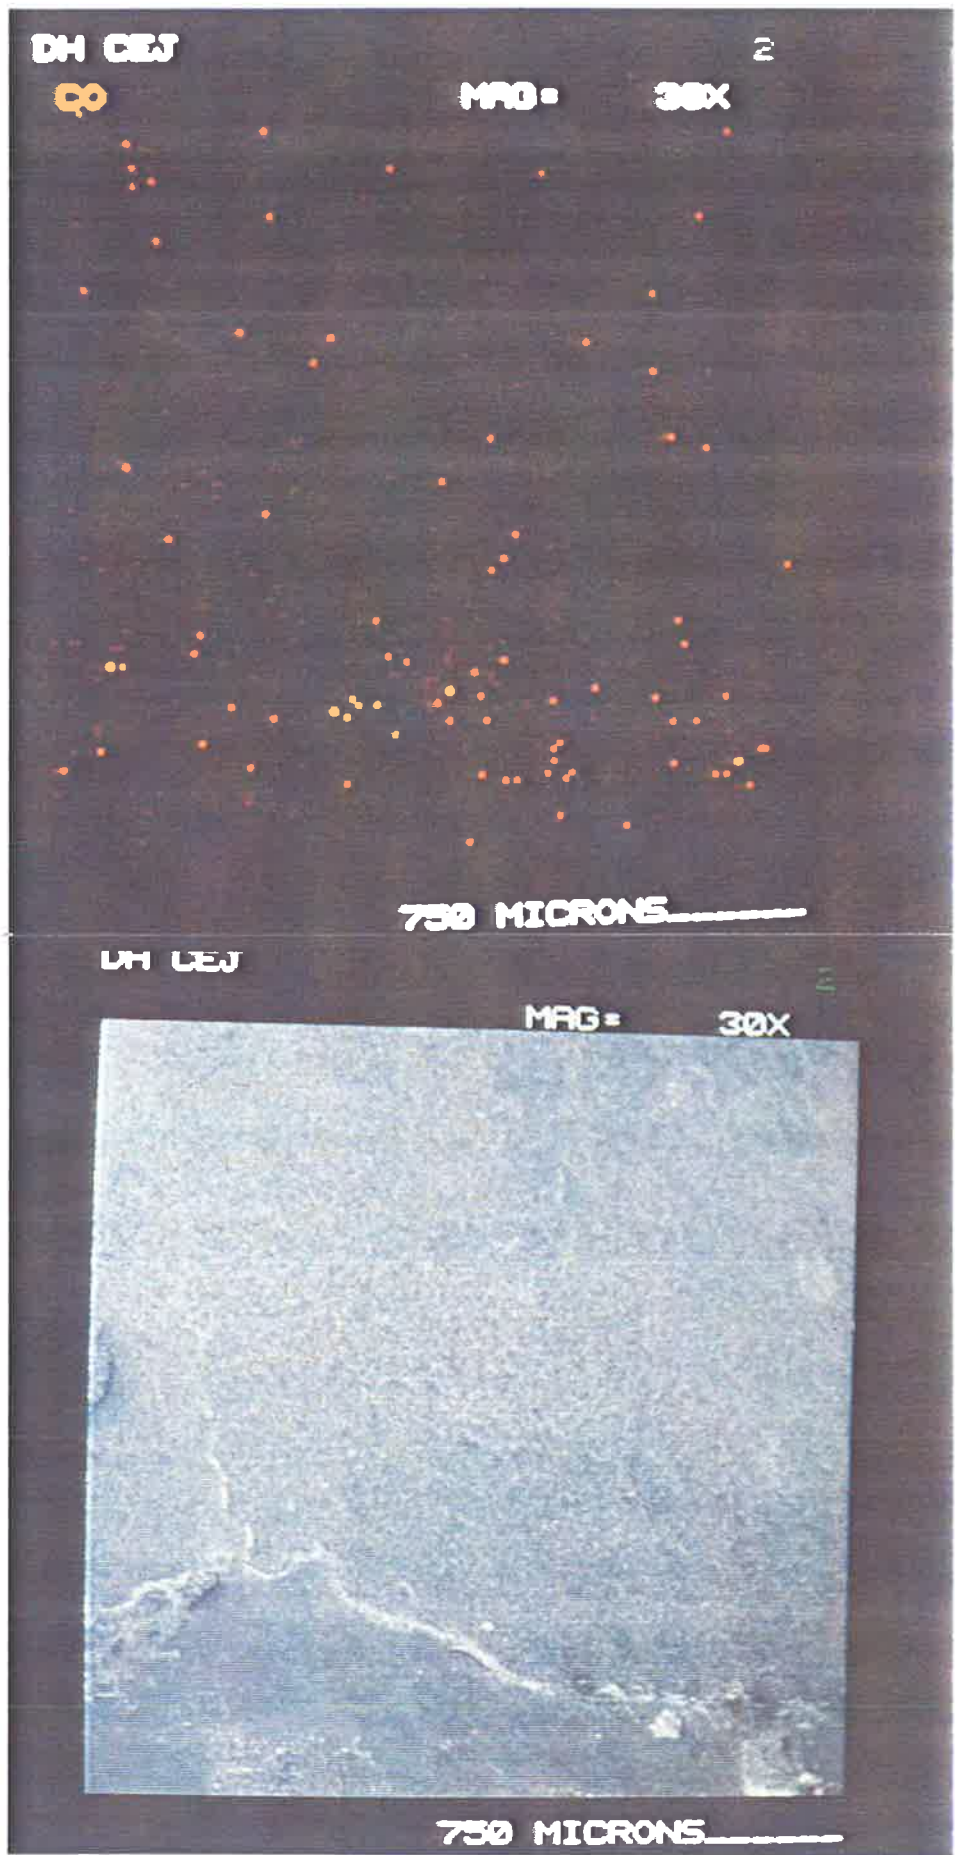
X-Ray Image Representing a Score of One (SEM Image top).
